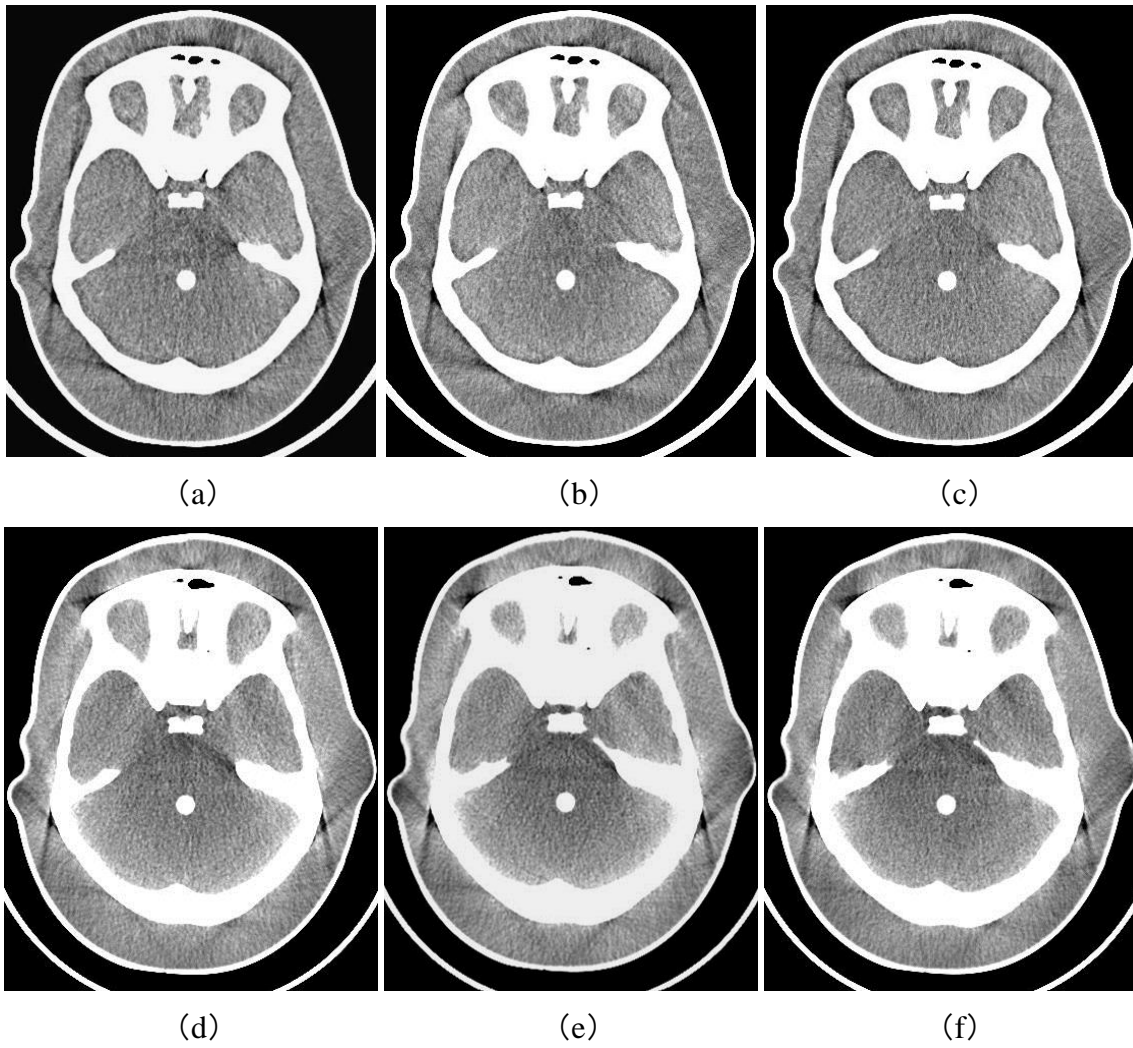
Representative skull base images generated using the (a) AS, (b) HS-64, and (c) HS-32 for the CT-A and (d) AS, (e) HS-64, and (f) HS-32 for the CT-B
